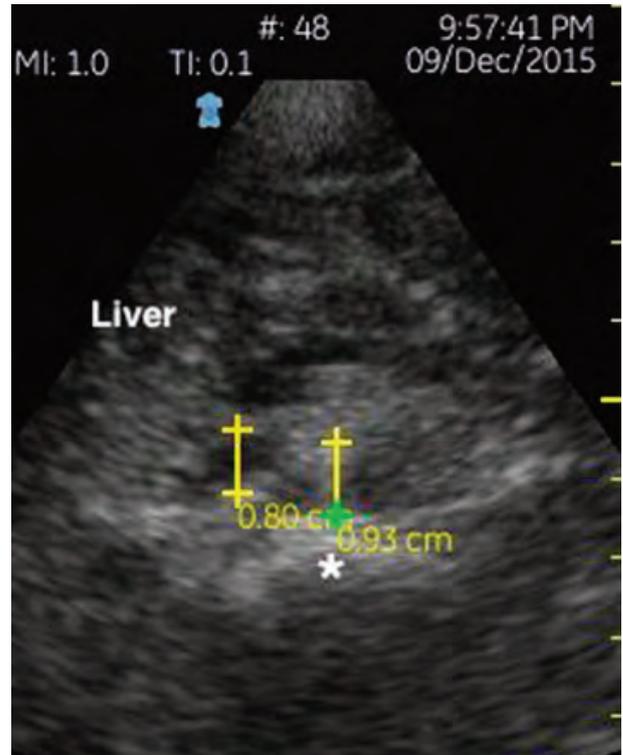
Infant IVC measuring 0.8cm and aorta measuring 0.93cm anterior to posterior transverse diameter. The IVC/aorta ratio is greater than 0.8 in this euvoletic infant. The aorta demonstrates pulsatile flow under color or power doppler (not pictured) and is located above the spine (*)
